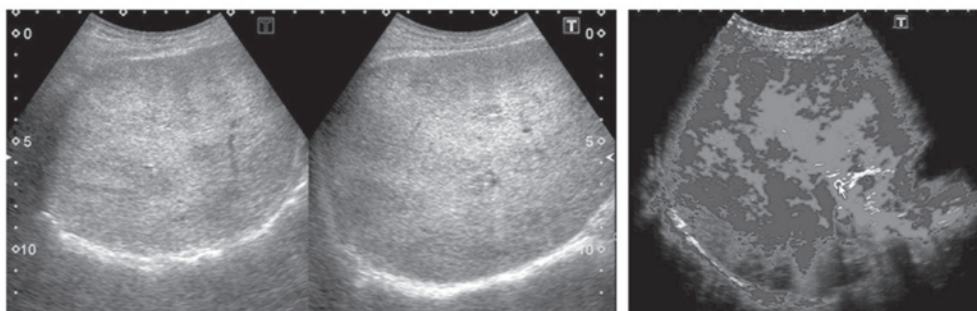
40yo, gentleman, acute alcoholic hepatitis. One year after recovering from the severe alcoholic hepatitis, his liver parenchyma became showing markedly irregular pattern on the B mode ultrasound. At the same time, perfusion parametric imaging was performed, and disproportional perfusion was observed within the liver parenchyma. Arterialization was observed at the high echoic area on B mode image, and low echoic area showed portal flow dominant (blue).
